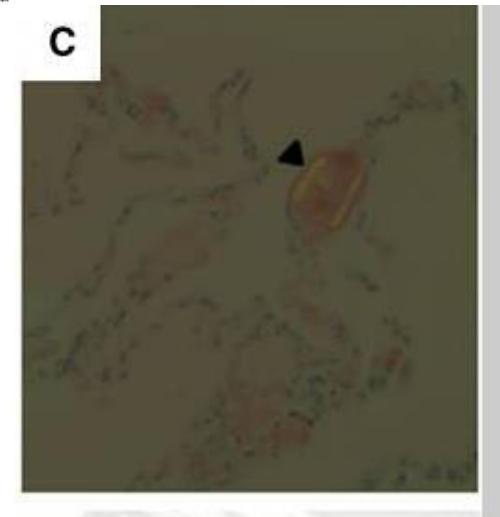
Axial high-resolution CT images (A, B) obtained in a 26-year-old man with localized pulmonary parenchymal amyloidosis demonstrating multiple bilateral peripheral-predominant thin-walled rounded cysts of varying sizes. Many of the cysts are subpleural in distribution. A calcified nodule (arrow) is present in the lingula.
